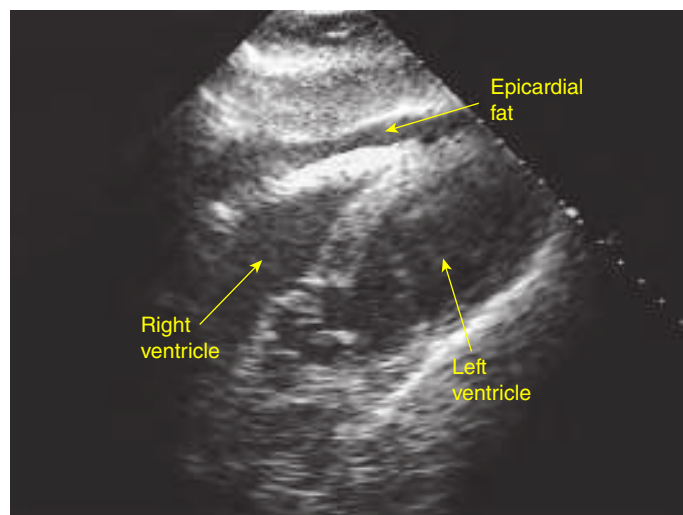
Subcostal long axis view of the heart demonstrating the epicardial fat pad anterior to the right ventricle. The epicardial fat pad is hypoechoic and not anechoic as usually seen with fluid. (Modified with permission from Ma OJ, Mateer JM, Blaivas M: *Emergency Ultrasound*, 2nd ed., McGraw-Hill, 2008.)
